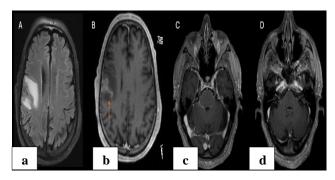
Leptomeningeal carcinomatosis in lung cancer patient (a) FLAIR axial image shows poorly defined hyperintensity in the right posterior frontal lobe, and (b-d) axial T1-weighted post-contrast sequences demonstrate multifocal nodular leptomeningeal enhancement involving the right posterior frontal region and pontine surface. Bilateral enhancement of cranial nerves V, VII, and VIII within the cerebellopontine angle cisterns confirms extensive leptomeningeal metastatic disease.
